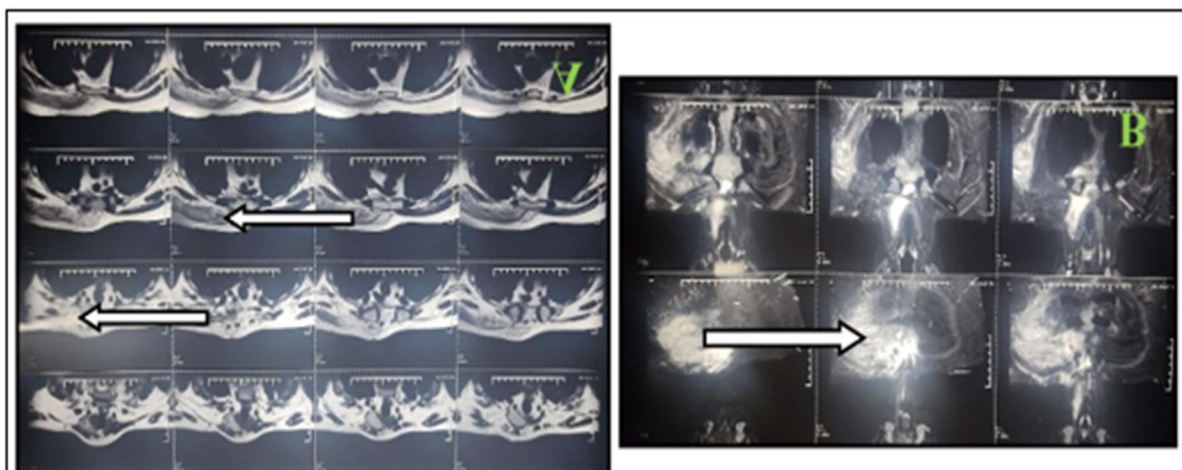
T2-weighted Magnetic Resonance Imaging films showing:
